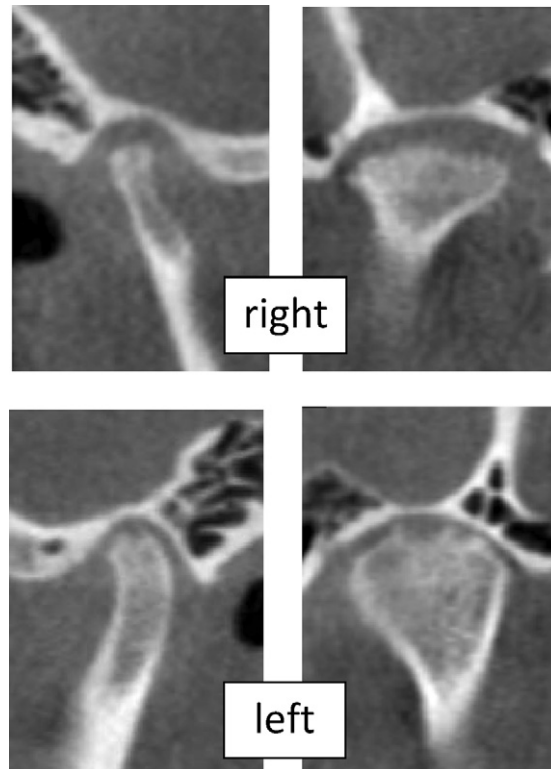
The cone-beam CT images of the right (above) and left (below) TMJ of the same patient on the same day are displayed. The right joint shows evidence of past change as indicated by lack of head bulge, small size, a medial spur, and flat superior surface. Additionally, the right joint demonstrates active changes, including condylar and fossa cortical irregularity, cortical breaks, and a singular subcortical bone cyst in sagittal view. The left TMJ (below) demonstrates normal size and shape, indicating that change has not occurred in the past. However, even without past left joint change, the cortex indicates that the joint is actively changing, as indicated by cortical irregularity, cortical breaks, and subcortical bone cysts. Both joints are in the process of condylar resorption, the right preceding the left. The head film and frontal bite photo for this patient are in shown in [Figure 5](#).
